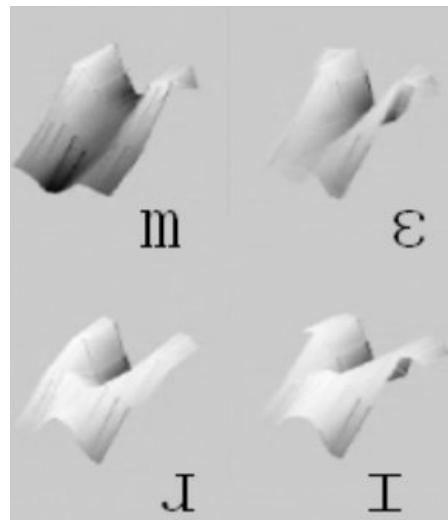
Reconstruction of 3D tongue movement during the word ‘merry’, using the multi-planar paced sonography method.
